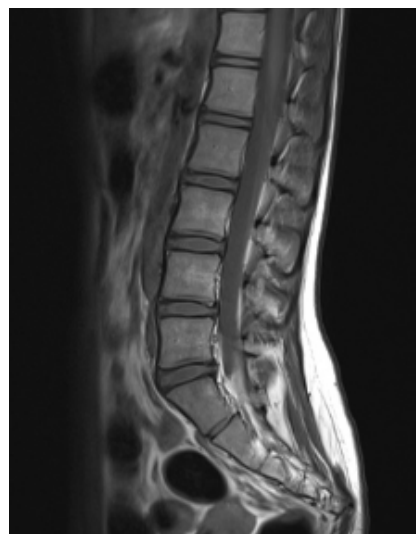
MRI lumbar spine.
